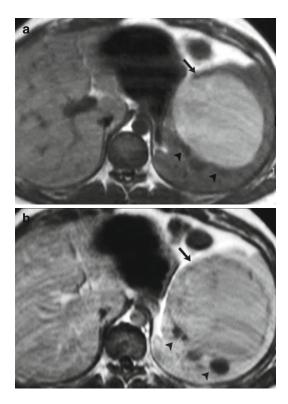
A 27-year-old woman with splenic lymphangioma. A complex cystic mass was detected on a previous routine sonography study and confirmed later on enhanced CT. Axial unenhanced (a) and contrast-enhanced (b) gradient-echo T1-weighted images show a subcapsular multilocular mass with hypo- (*arrowheads*) and hyperintense (*arrow*) non-enhancing areas, revealing their cystic nature. Hyperintense areas were secondary to proteinaceous content. Diagnosis was confirmed after splenectomy. Artifact was the result of poor breath holding (With permission from Luna et al. [57])
